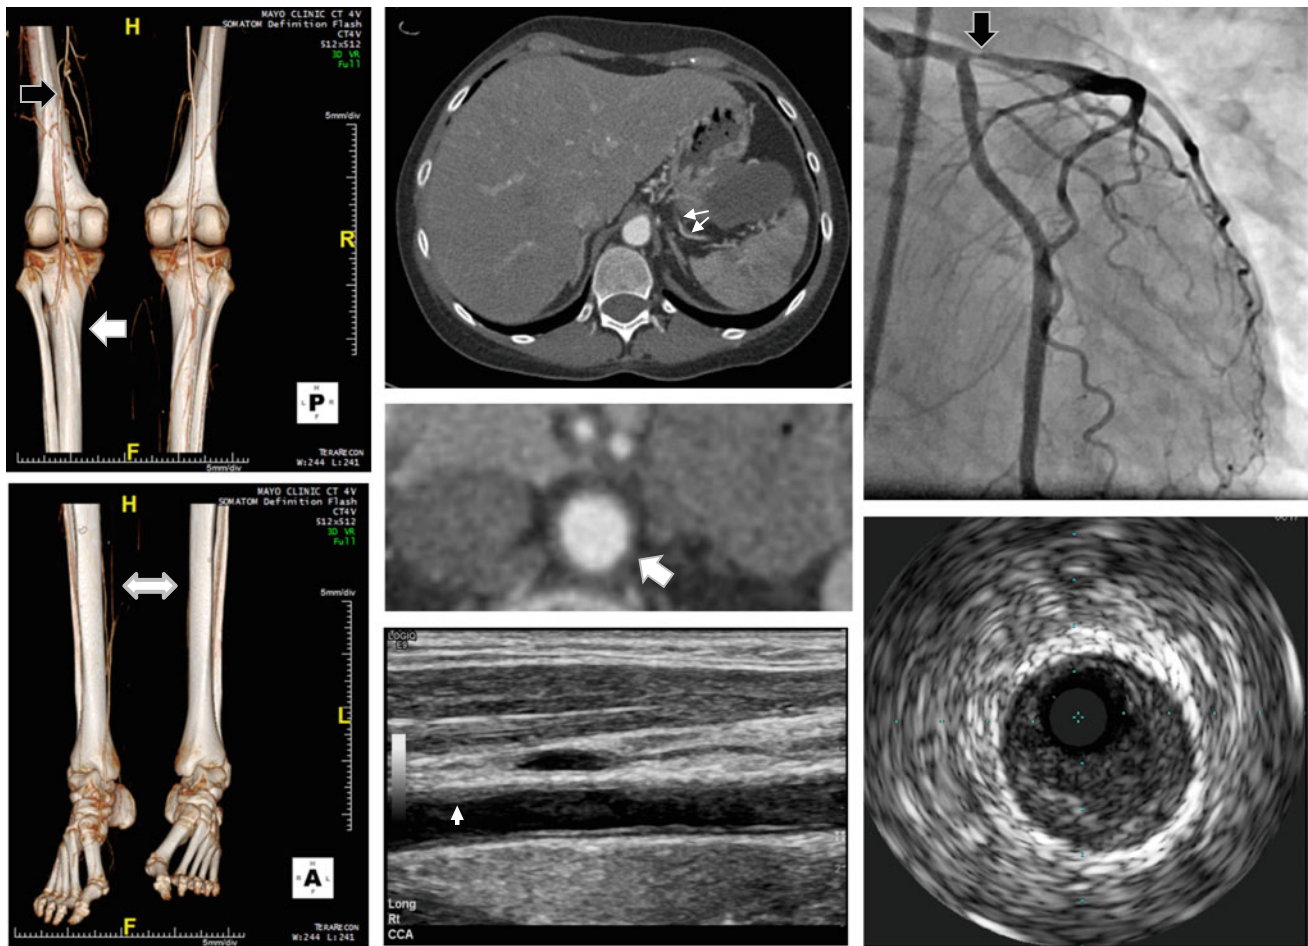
Left upper and lower panels: Computed tomography angiography (CTA) with 3D reconstruction showing occlusion of the left superficial artery (black arrow) and poor runoff thereafter (white arrow) and poor distal circulation bilaterally (white double arrow), especially near the left; upper middle panel: abdominal CTA showing multiple stenoses of the splenic artery (arrows) and circumferential thickening of the wall of the infrarenal aorta (arrow); lower middle panel: ultrasound of the right common carotid artery showing focal atherosclerotic plaque (arrow) and diffuse intimal thickening on
